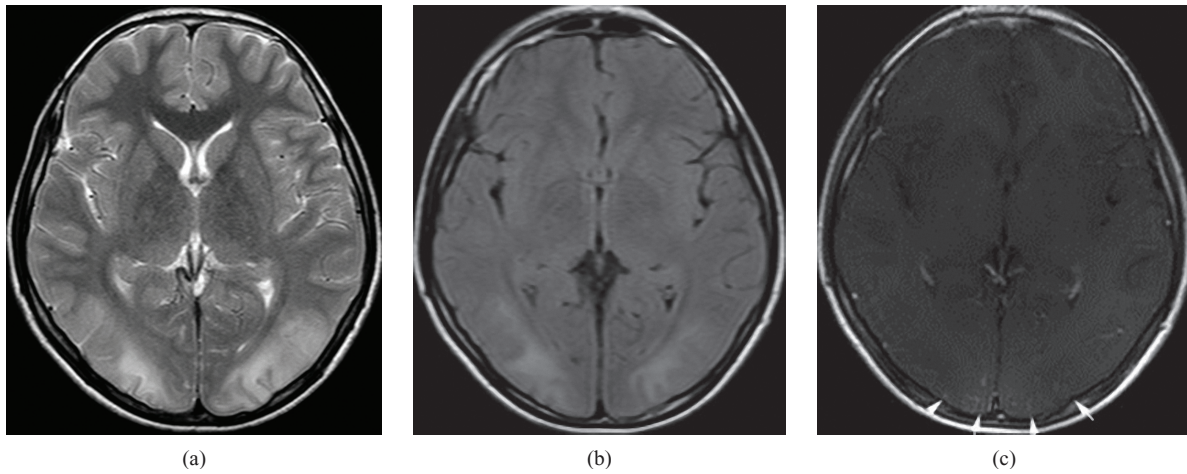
T2 TSE (a) and T2 FLAIR (b) images show bilateral symmetric hyperintensities in the white matter and cortex of the parietal and occipital lobes. Contrast enhanced T1 weighted image (c) reveals minimal leptomeningeal enhancement (arrows).
